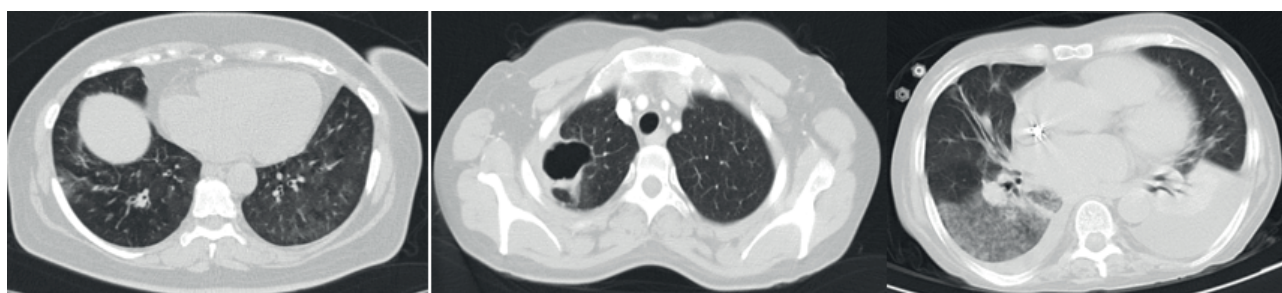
Images of Thorax CT from both ANCA associated vasculitis subtypes, MPAN, GPA (wegener), and EGPA (Churg Strauss), respectively
